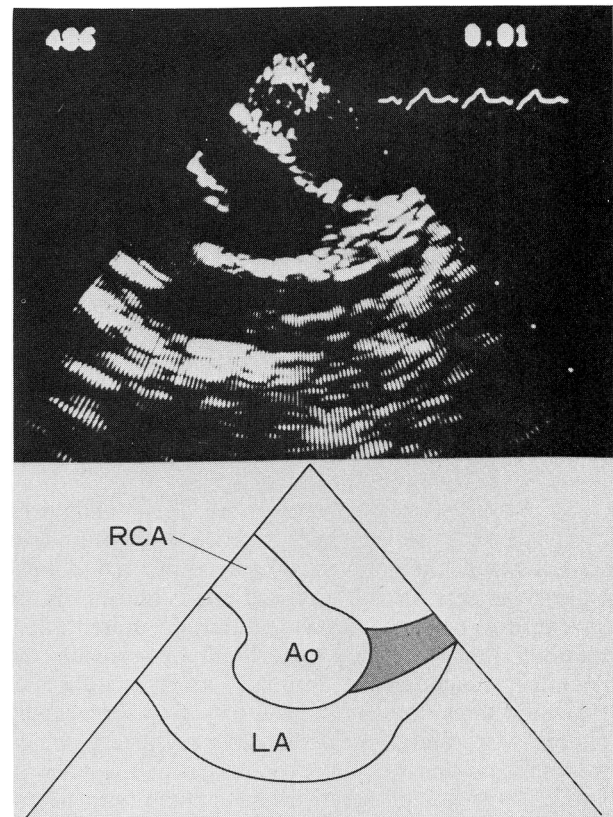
Cross-sectional echocardiogram from a patient with a fistula between the right coronary artery (RCA) and the right ventricle. The two parallel linear echoes of markedly wide lumen originating from the anterior portion of the aorta (Ao) are clearly shown. LA = left atrium.
